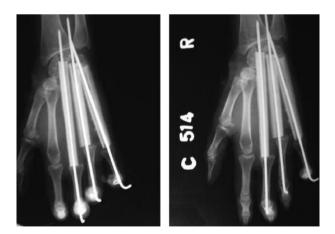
Radiograph of the right hand showing excision of 3^{rd} , 4^{th} (grafted fibular strut) and 5^{th} metacarpal and reconstruction with fibular grafts fixed with K-wires.
